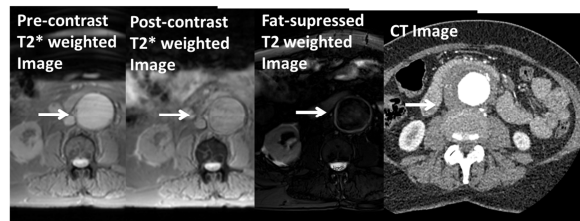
Images involved: from left to right, pre- and post-contrast T2*W image, T2W image with fat-suppression, CT image, white arrow pointing to aorta.
